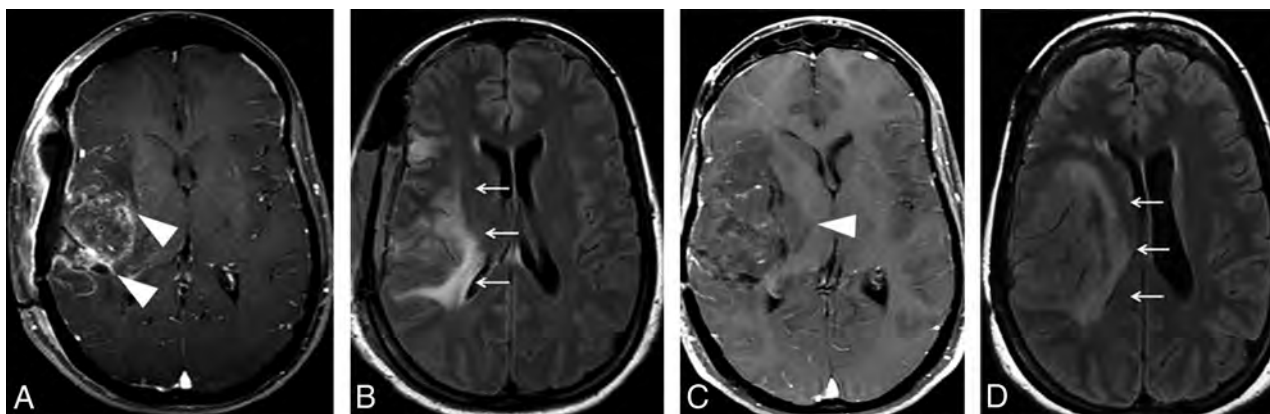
Pseudoresponse in a 36-year-old woman with a partially resected GBM in the right temporal lobe and insula. Axial contrast-enhanced T1-weighted (A) and FLAIR (B) images obtained in the immediate postoperative period show an extensive hyperintense FLAIR lesion (arrows) with multiple foci of contrast enhancement (arrowheads). C, An anti-VEGF agent was administered, and a follow-up axial contrast-enhanced T1-weighted image depicts a striking decrease of the enhancing component (arrowhead). D, However, there is also an increase of the nonenhancing infiltrative component, manifested as FLAIR hyperintensity in the right frontotemporal region and insula, with an expansive effect, blurring, and loss of the cortical-subcortical differentiation (arrows).
